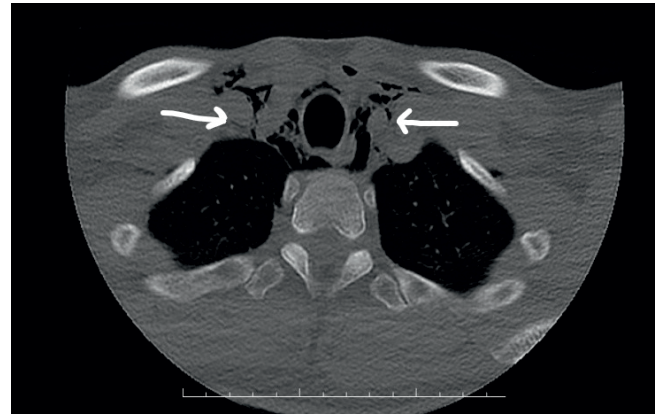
Air bubbles in the paratracheal area and under the skin as seen in PA chest X-ray (arrow)
